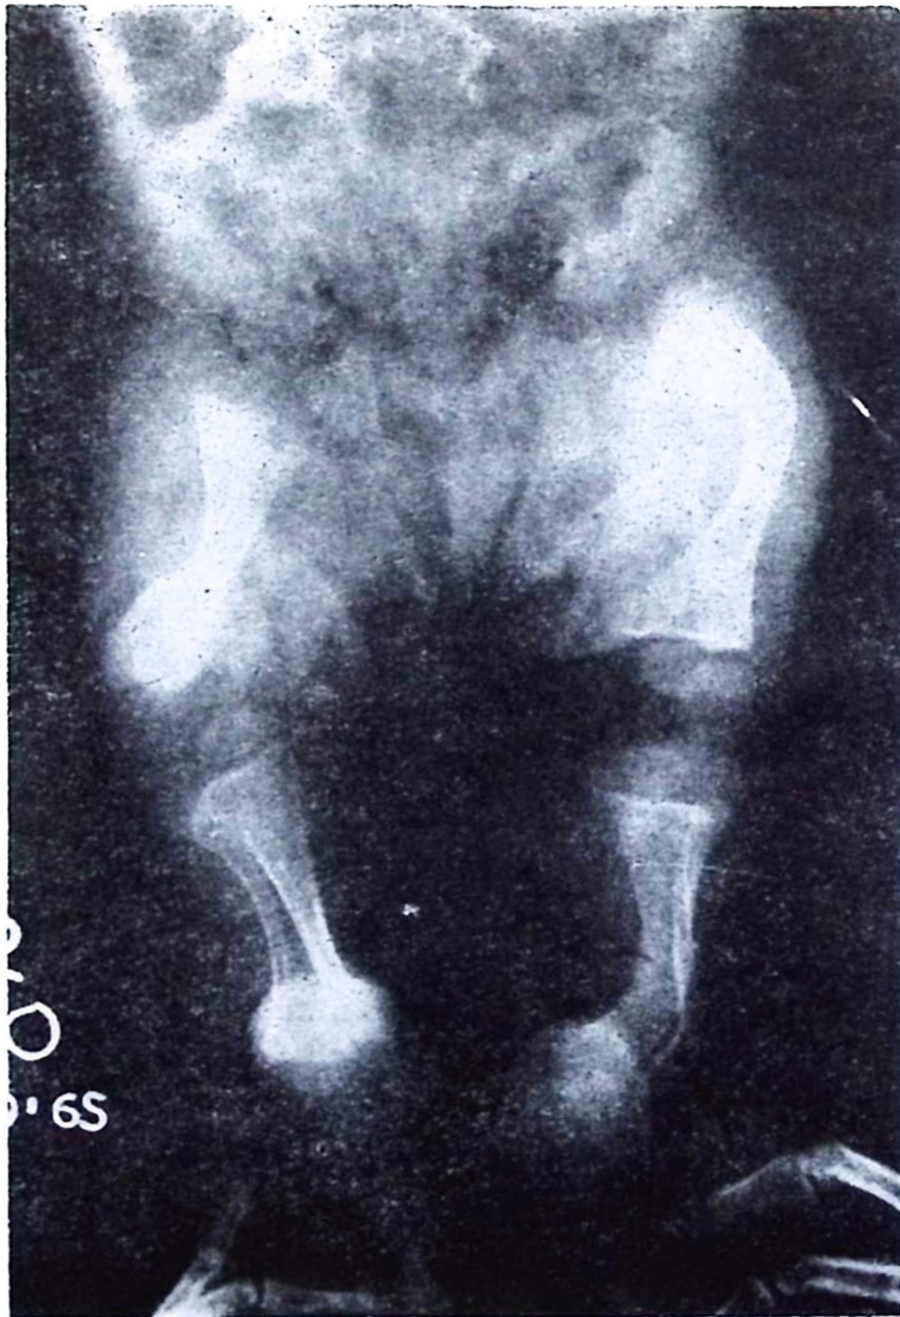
X-ray of lower extremities after two months of treatment shows slight thickening and more regular appearance of the cortices, and healing of fractures with good medulla formation.
